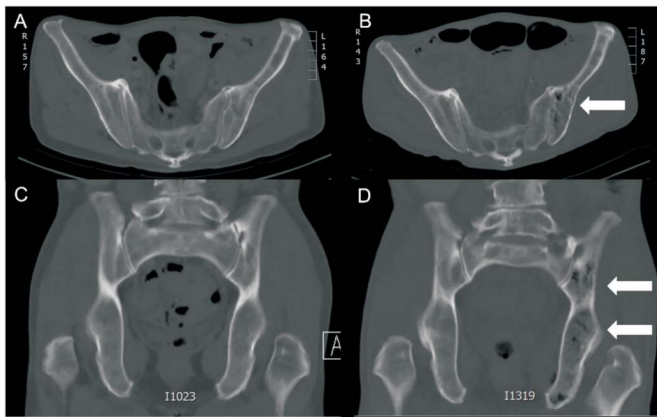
Computed tomography of abdomen. A and C (left panel) axial view (A) and coronary view (C) of iliac bone 2 months before diagnosis of emphysematous osteomyelitis; the bone structure was intact. B and D (right panel) axial view (B; arrow) and coronary view (D; arrows) that indicate intraosseous gas in left iliac bone.
